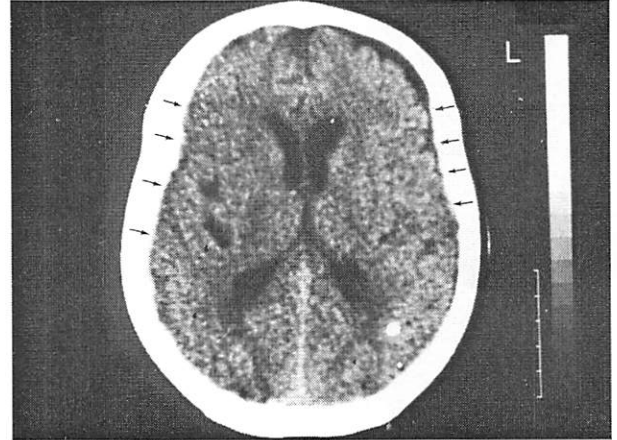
Noncontrast axial CT reveals bilateral acute subdural hematoma on the cerebral convexities (arrows).
